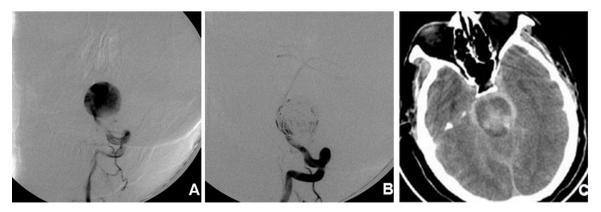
A left vertebral artery giant aneurysm. A 77-year-old male presented with severe headache, gait disturbance, dysarthria, nystagmus and hypoesthsia. (A) Left vertebral artery angiogram (frontal views) showed a giant saccular aneurysm located at left vertebral artery, which was treated by stent-coils embolization. (B) Post-operative angiogram in frontal views: giant aneurysm was embolized incompletely. (C) Emergency post-operative CT scan showed subarachnoid hemorrhage from the rupture of the giant aneurysm. The patient lost consciousness rapidly and died 3 days later.
